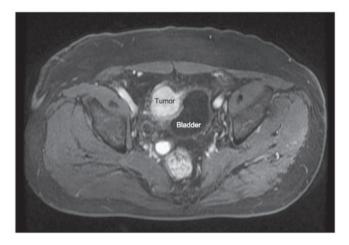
Dynamic contrast-enhanced magnetic resonance image of a patient who presented with discomfort on urination at the initial visit. The image demonstrates tumor infiltration of the urinary bladder, which may have been responsible for the symptoms.
